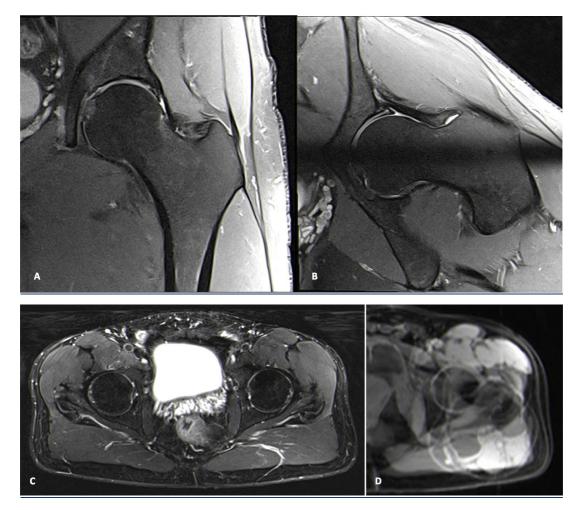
Sequences that should be included on the proposed routine MRI protocol for the assessment of suspected FAIS, include unilateral hip 2D sequences (coronal, axial oblique and sagittal are most useful), radial imaging (either a 2D sequence or reformats from a 3D acquisition), a pelvic fluid-sensitive sequence
